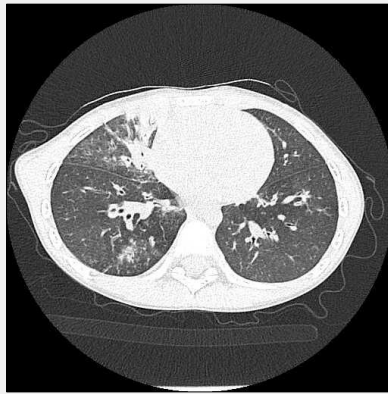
The plain CT scan of the chest.
